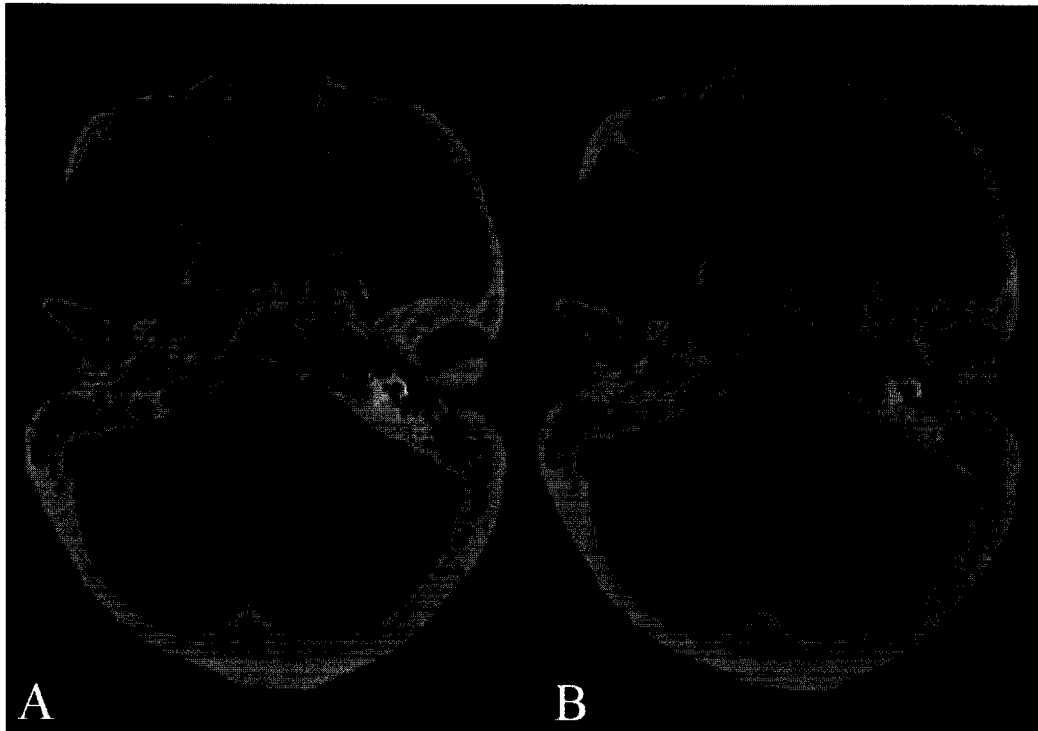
A) Single CT slice of fresh frozen skelton. B) CT after anisotropic smoothing.
